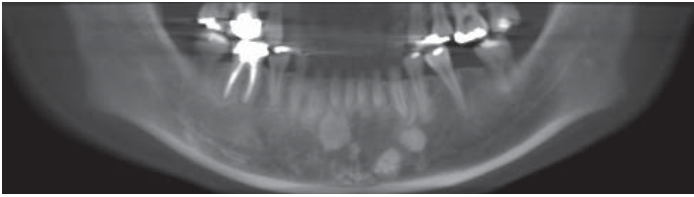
Panoramic image reconstructed from cone-beam CT data showing multiple radiopacities in the mandible depicting dense bone islands.
